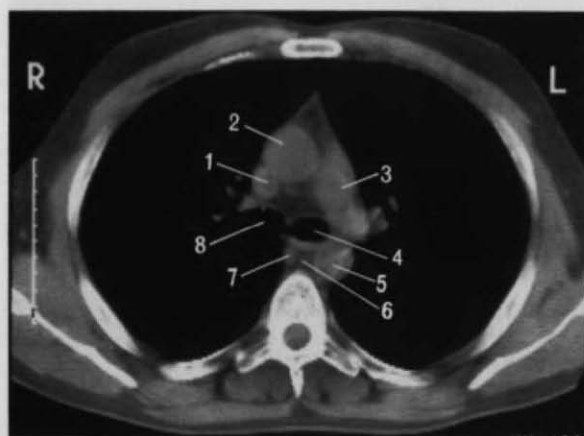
CT scan, just below the level of the tracheal bifurcation, viewed from below: 1 — superior vena cava, 2 — ascending aorta, 3 — left pulmonary artery, 4 — left main bronchus, 5 — thoracic aorta, 6 — oesophagus, 7 — azygos vein, 8 — right main bronchus.
